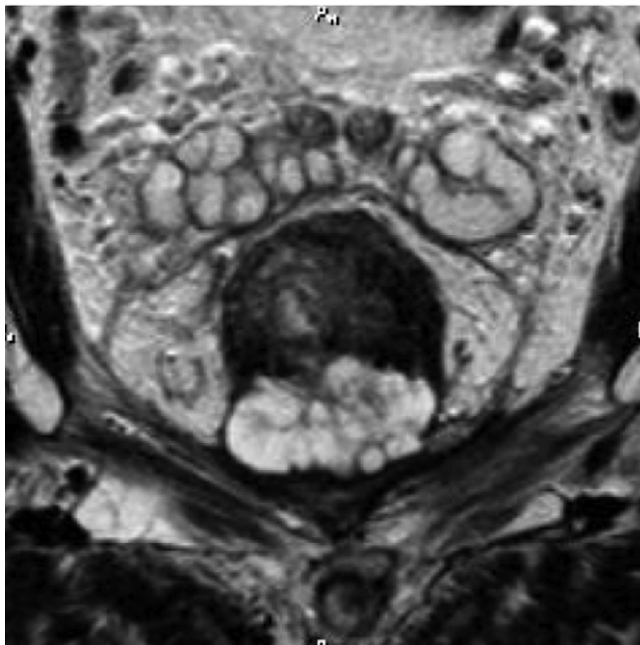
Axial T2-weighted magnetic resonance imaging (MRI) demonstrating mucinous adenocarcinoma invading the posterior compartment.
